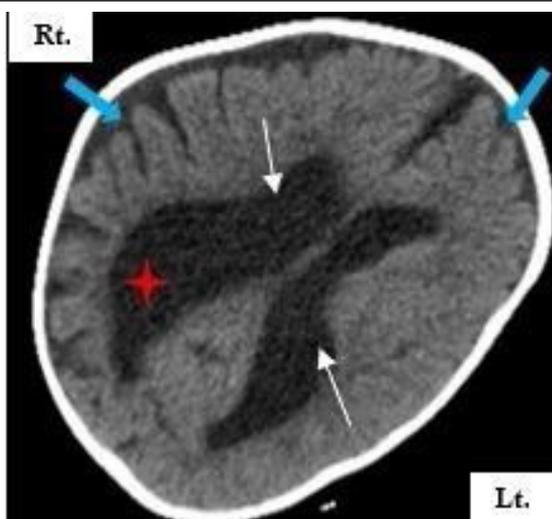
Brain CT scan revealed bilateral ventricular dilatation (line arrows), more prominent in the right occipital horn (star), along with small bilateral subdural hygromas (arrows), and diffuse cerebral atrophy.
